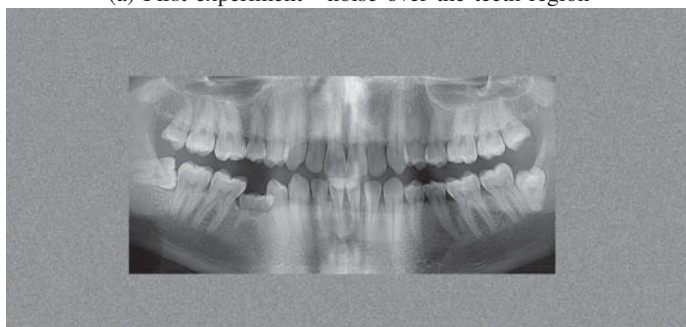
Panoramic X-ray image examples
